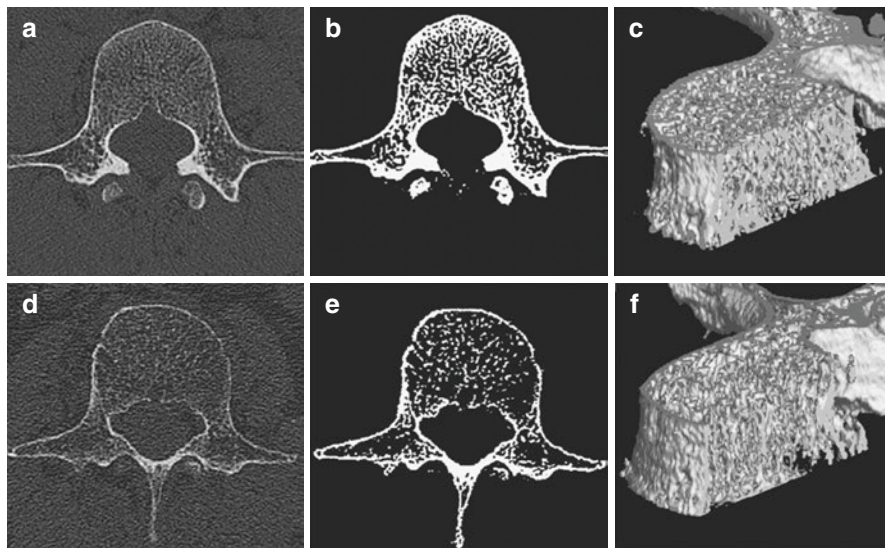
Trabecular microstructure using multi-detector row CT (MDCT). Representative 2D and 3D MDCT images of the third lumbar spine. (a and b) 2D and (e and f) 3D MDCT images of the third lumbar spine were obtained from (a and e) a 62-year-old woman without vertebral fracture and (b and f) a woman of the same age with a vertebral fracture in her thoracic spine. (c and d) Binarized images are also shown [11]
